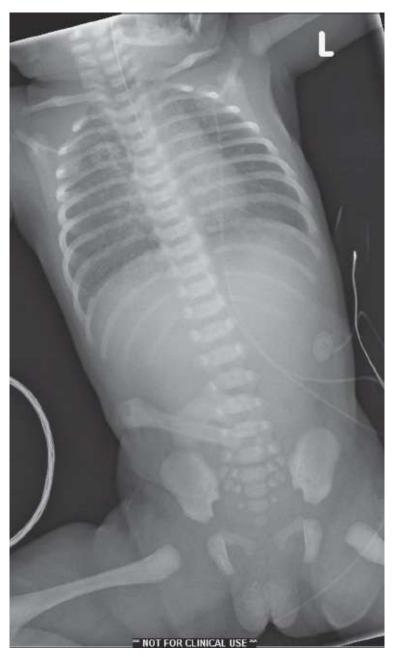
Radiographic findings of esophageal atresia. Note the orogastric tube ending in upper chest and the absence of bowel gas, suggesting pure esophageal atresia without any communication between the airway and gastrointestinal tract.
